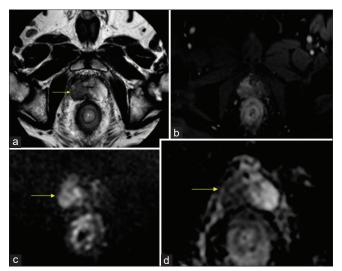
multiparametric magnetic resonance imaging prostate (a) PIRADS 5 lesion at right peripheral and transition zones (arrowed) with extraprostatic extension and local infiltration to bilateral seminal vesicles, right neurovascular bundle; (b) dynamic contrast enhancement post-gadolinium; (c) lesion markedly hyperintense on high b-value on diffusion-weighted imaging; (d) focal markedly hypointense lesion on apparent diffusion coefficient
